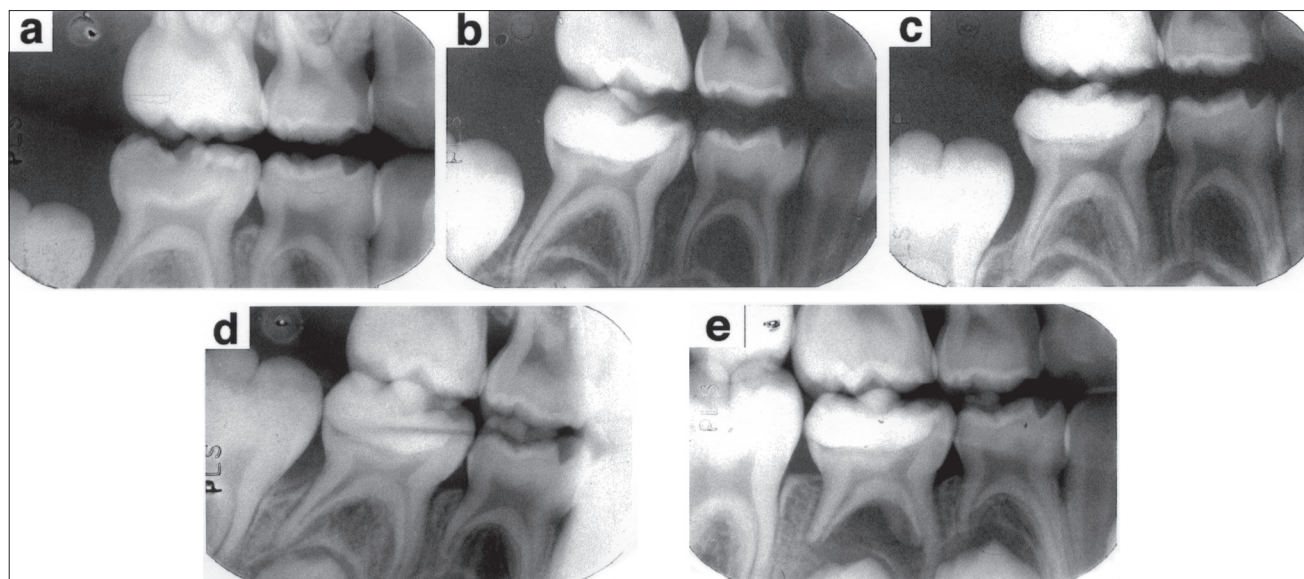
Radiographic evaluation of a mandibular second primary molar that received indirect pulp treatment with calcium hydroxide and was considered a failure after 18 months. Preoperative radiograph (a), immediate postoperative (b) and 6 months (c), 12 months (d) and 18 months (e) after indirect pulp treatment. The interradicular lesion accompanied by external root resorption observed in panel (e) was indicative of treatment failure.
